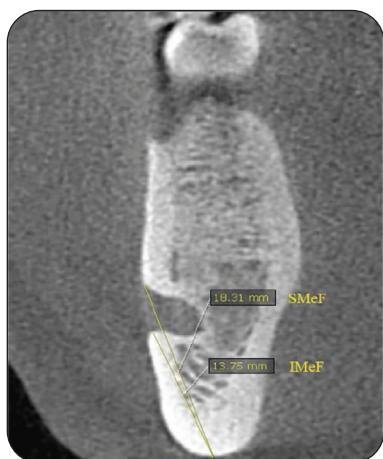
SMeF & IMeF measurements on the coronal cut of a CBCT radiograph
